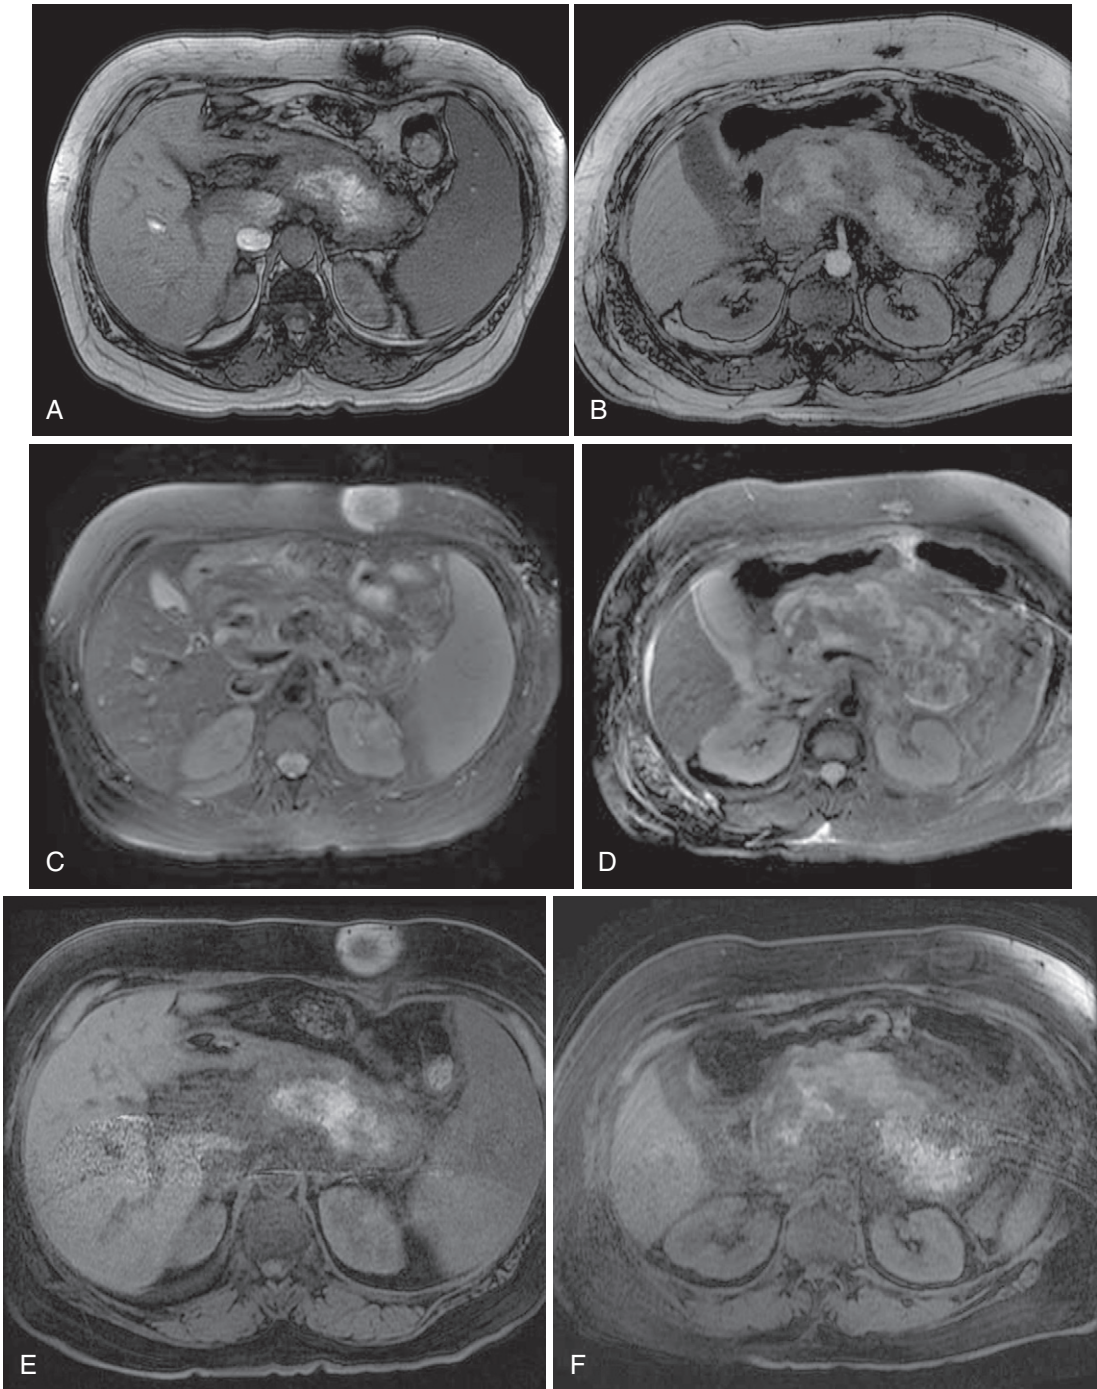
Acute hemorrhagic pancreatitis. Out-of-phase T1-weighted gradient recalled-echo (A and B), fat-suppressed T2-weighted (C and D), and fat-suppressed T1-weighted gradient recalled-echo (E and F) images demonstrate marked acute pancreatitis with increased T1-weighted signal intensity and corresponding decreased T2-weighted signal intensity related to hemorrhage, as well as marked peripancreatic inflammation.
